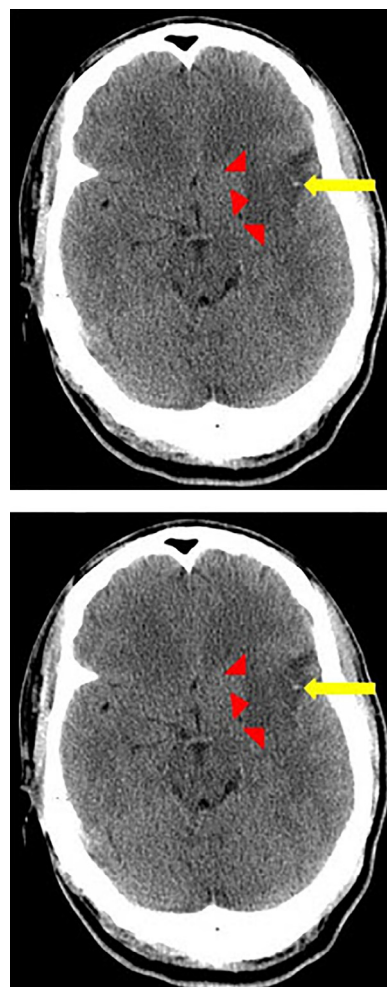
Axial computed tomography image demonstrates indistinct low density (red arrows) involving the left basal ganglia and external capsule, consistent with an acute ischemic infarct involving the left middle cerebral artery (MCA) vascular territory. Additionally, a hyperdense left MCA (yellow arrow) is present, concerning for a thrombotic event.
